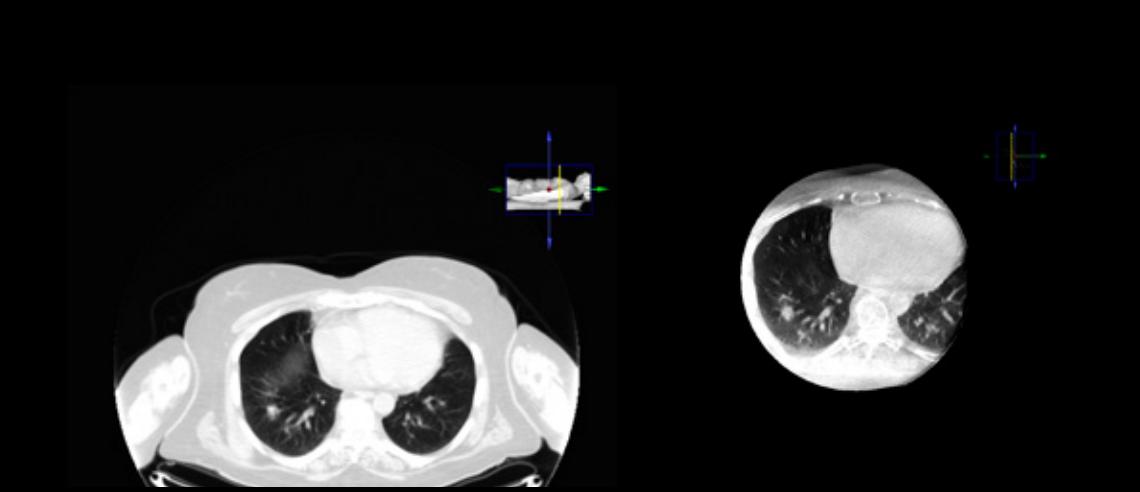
Pre-operative CT (left) and intra-operative cone beam CT (right) showing small right lower lobe pulmonary nodule.
